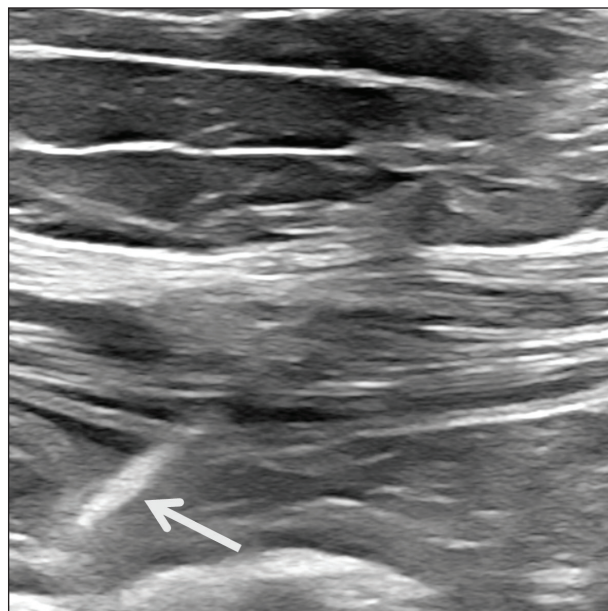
Ultrasound-guided access with the tip of the needle (arrow) in the peritoneal cavity.
